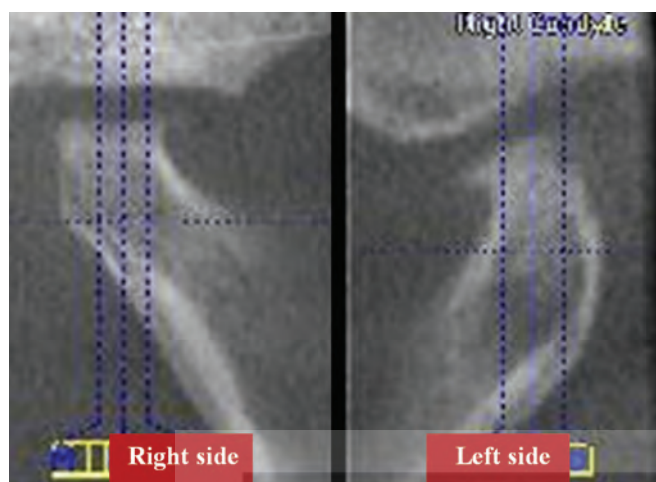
X-ray images showing osseous changes of bilateral condyles
